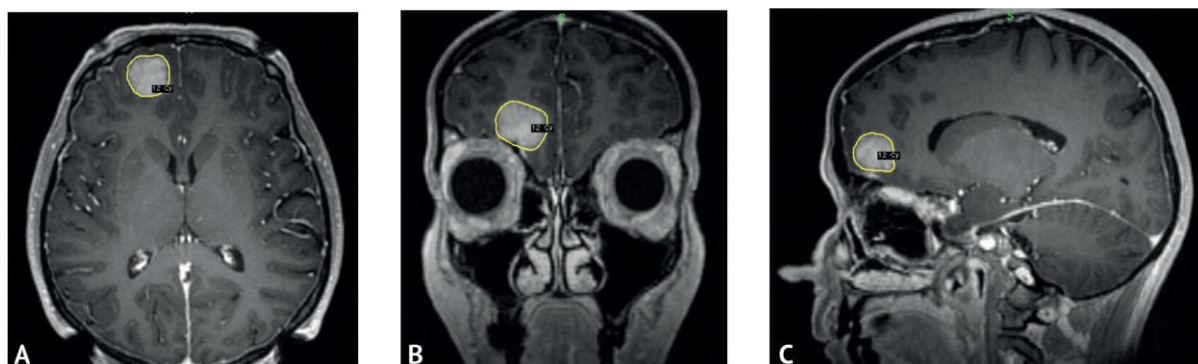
Plan of stereotactic radiosurgical treatment. The images were obtained from the Gamma-Plan radiosurgical treatment planning station. On T1-weighted MRI scans, obtained after intravenous administration of a contrast agent, the yellow line indicates the prescribed dose limit of 12 Gy, corresponding to the edge of the tumor. The letters A, B, C denote images in axial, coronal and sagittal planes, respectively
